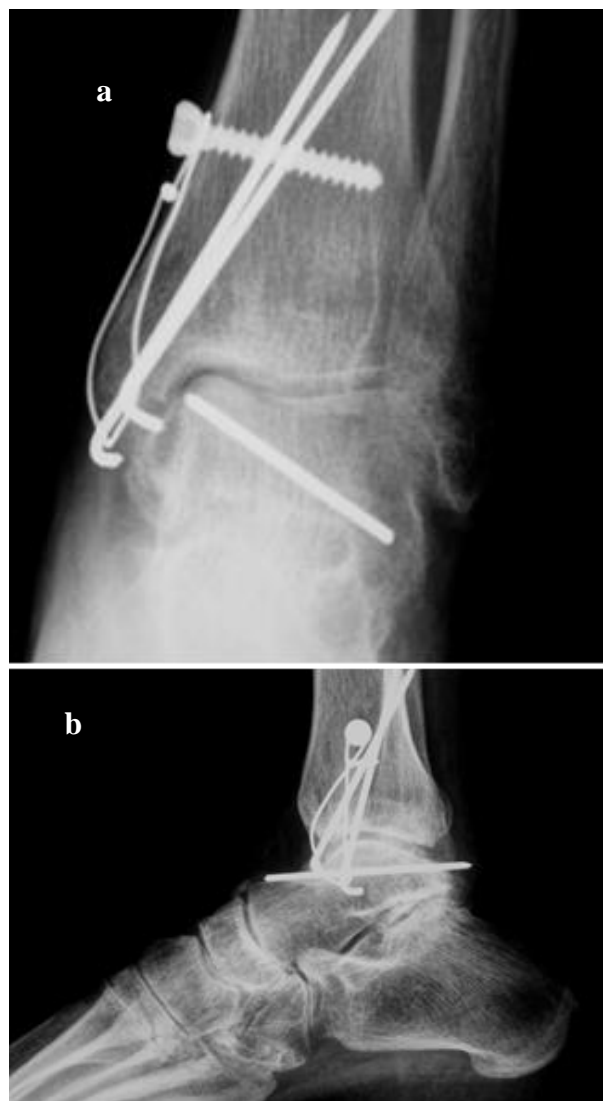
Postoperative X-rays after ORIF with tibial transmalleolar approach
